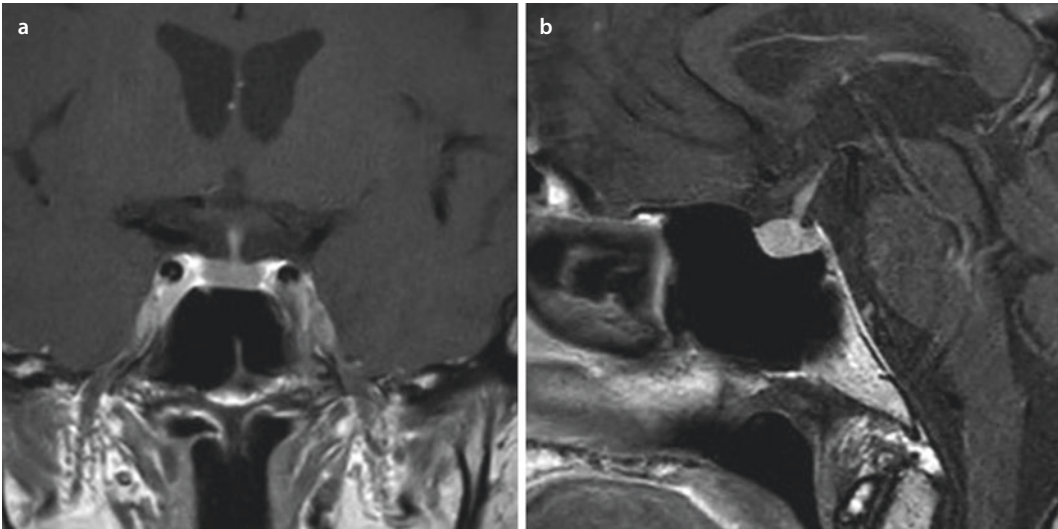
Coronal a and sagittal b cross-section of a normal sella MRI showing no signs of a micro- or macro-adenoma
